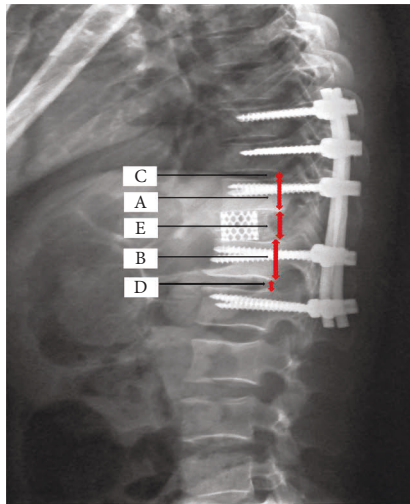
Range of spinal shortening and percentage of spinal shortening of single spinal motion segment (total height of posterior edge of vertebral body+cephalad disc+caudal disc) were calculated using the following equation on the postoperative lateral radiograph. Range of Spinal shortening: $X = (A + B)/2 + C + D - E$, percentage of spinal shortening of single spinal motion segments: $Y = X / [(A + B)/2 + C + D] \times 100\%$, where A is the height of posterior edge of cephalad vertebral body, B is the height of posterior edge of caudal vertebral body C is the height of posterior edge of the cephalad disc, D is the height of posterior edge of caudal disc, and E is the height of posterior edge of titanium mesh.
